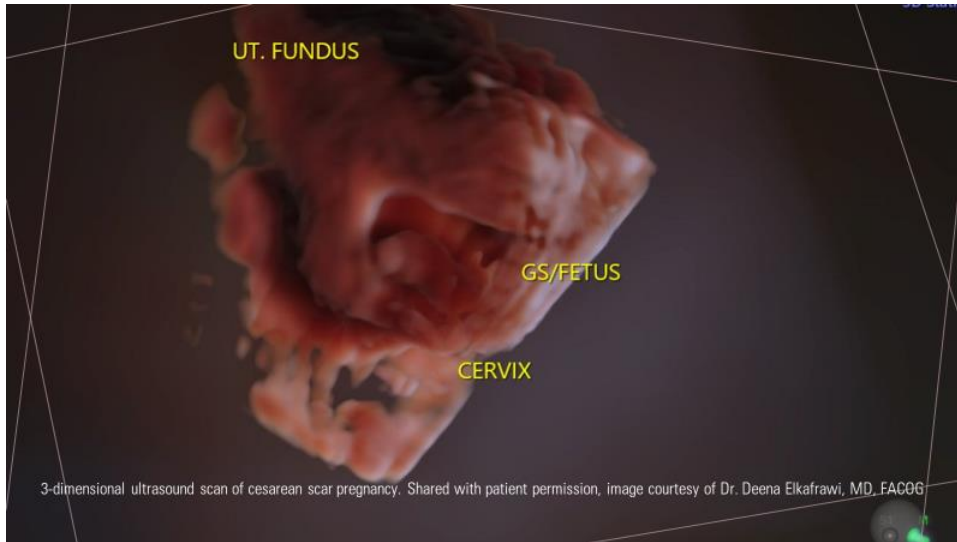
3-Dimensional ultrasound scan of cesarean scar ectopic pregnancy.
